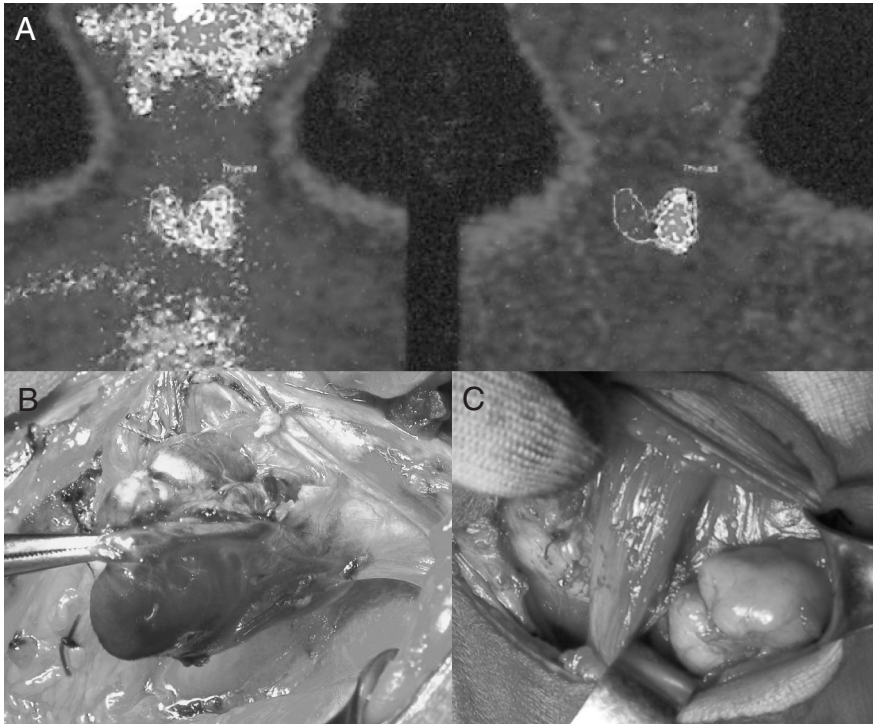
A-B: Parathyroid ^{99m}Tc e ^{99m}Tc MIBI scintigraphy evidencing a hypercaptating area on the left side after electronic subtraction of the radionuclides. C: Left parathyroid adenoma. D: On the left side of the sternocleidomastoid muscle insertion on sternum, left thyroid lobe where the parathyroid adenoma was resected and the lymphatic mass on the right side.
